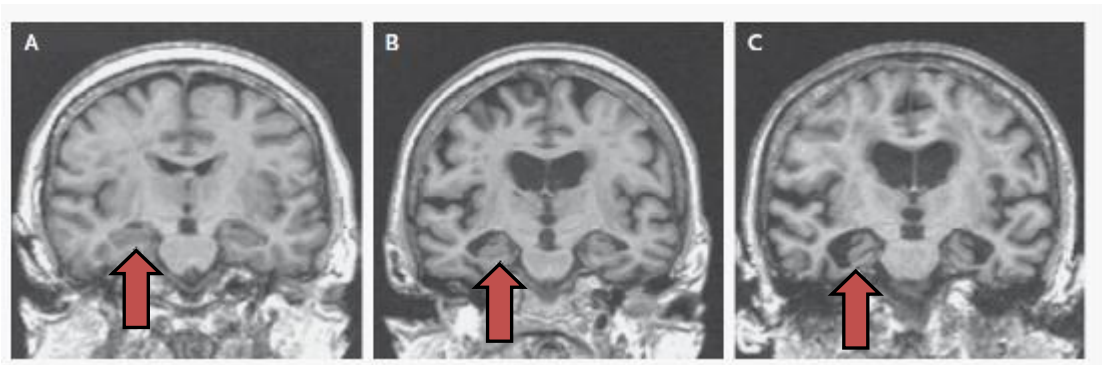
MRI scan images: (A) normal elderly (B) MCI patient (C) AD patient (Petersen, 2011)
